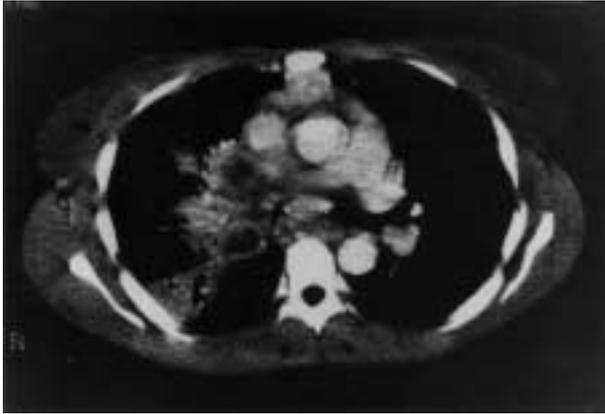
Computed tomographic (CT) scan shows necrotic lymph nodes, pulmonary infiltrate and consolidation of apical segment of the lower right lobe.
